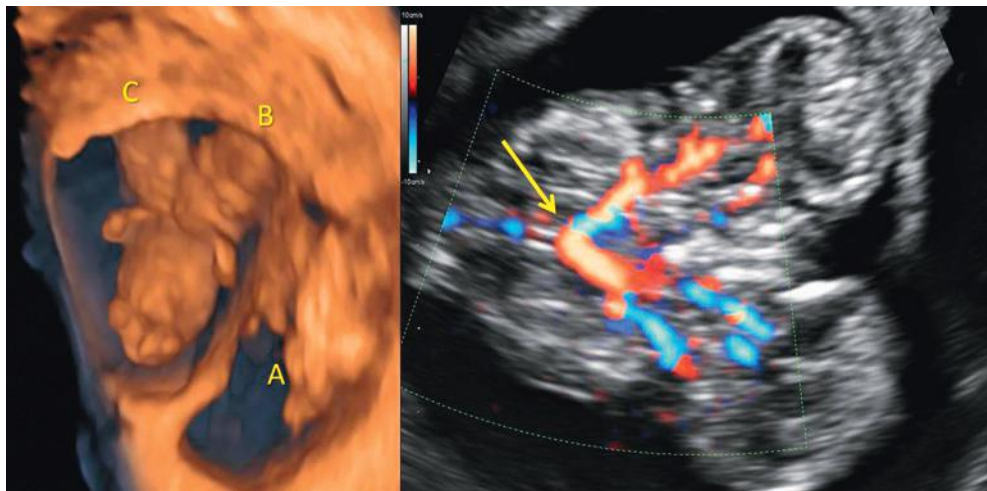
Dichorionic diamniotic triplet pregnancy with parapagus dicephalus conjoined pair (B and C). Color Doppler flow imaging (*right*) demonstrates the head and neck vessels of B and C arising from a single heart (*arrow*).
